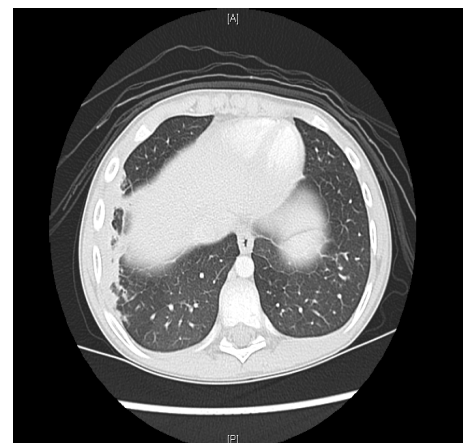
Chest CT with a minimal residual pleural effusion
